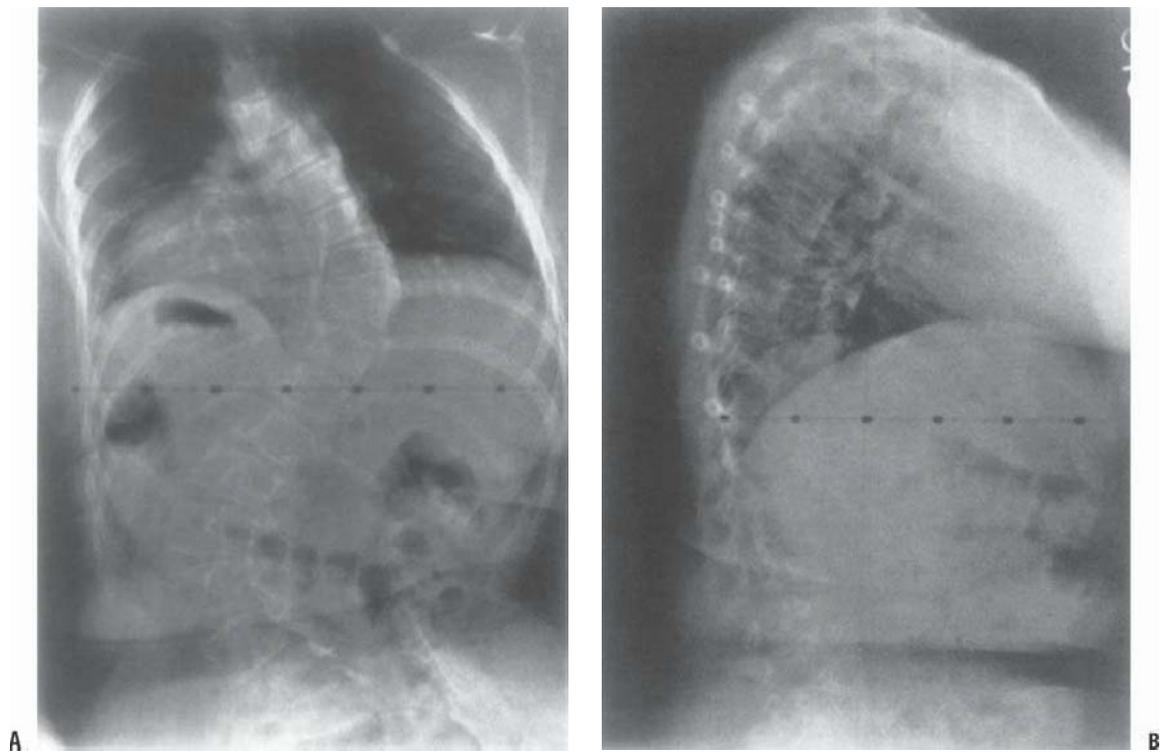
Dunn McCarthy Pelvic Fixation. Measurement from the preoperative radiographs aids in achieving the correct dimensions of the bends. The first consideration is that the midportion of the sacral ala is lateral to the midportion of the lamina. This amount of lateral offset in the rod (A) can be estimated by measuring the distance from the midportion of the L5 lamina to the midportion of the sacral ala. In the typical patient, this is about 1 to 1.5 cm. The width of the segment that is to go over the sacral ala (B) is measured from the lateral radiograph of the pelvis. This width is usually between 1 and 1.5 cm. When this procedure is used in the bifid myelodysplastic spine, careful preoperative planning is necessary to be sure that the rod lies in the desired position. At surgery, the sacral ala is cleaned as it would be for lumbosacral arthrodesis. It is important that the hook portion of the rod passes anterior to the alae, thus necessitating the dissection be carried out slightly more anterior than usual. Before seating the rod, it should be possible to pass a finger around the front of the alae.
